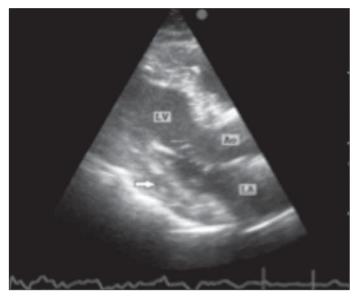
Parasternal long-axis echocardiographic view of intramyocardial fissure (arrow)
